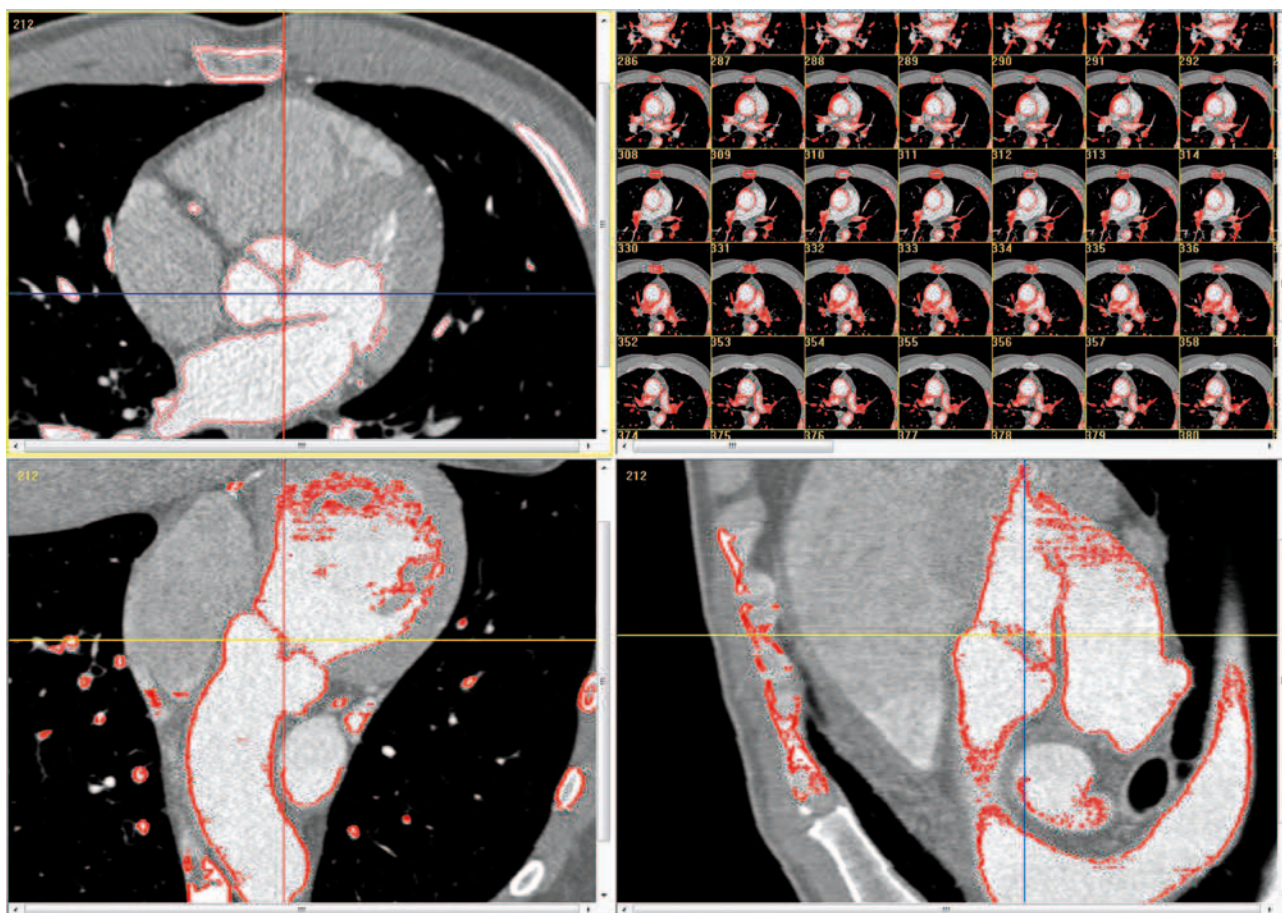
CT image segmentation; ROI (regions of interest) marked in 3D-DOCTOR software (Able Software Corp.)
